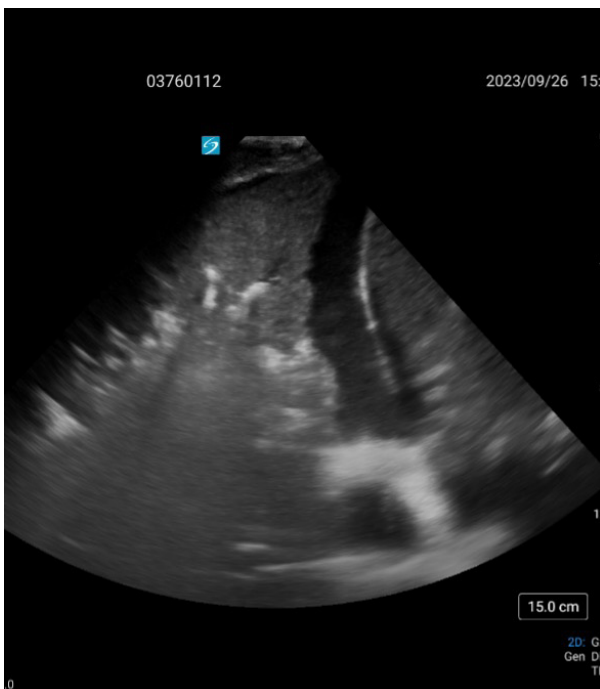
Lung ultrasound score 1
